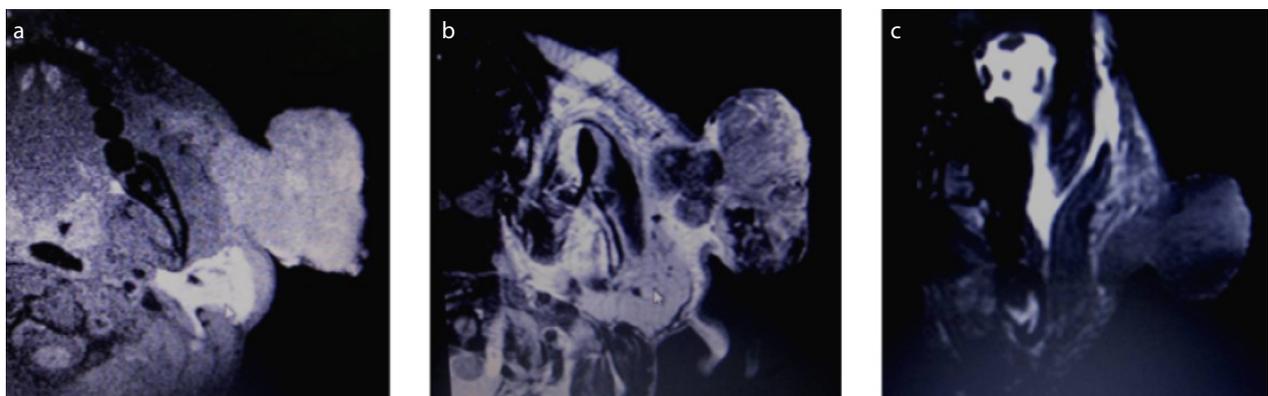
a-c. Pre-operative MR images. (a, b) axial sections, (c) coronal sections
